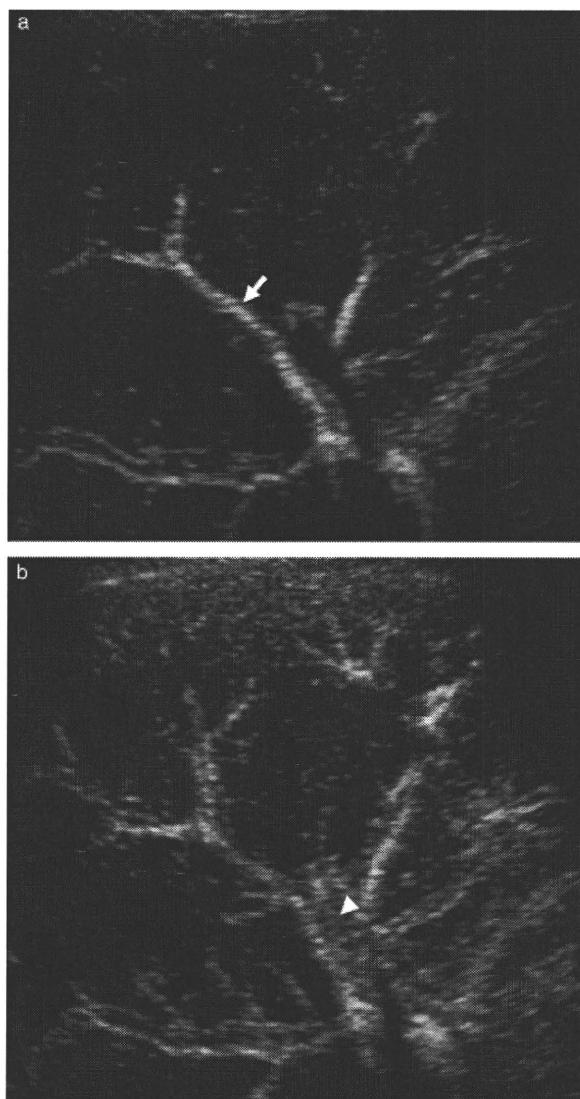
Contrast-enhanced ultrasound images under right intercostal scan. (a) Onset time of contrast enhancement in the right hepatic artery: onset time of contrast enhancement was 14 s after the injection of Sonazoid™ in the right hepatic artery (arrow). (b) Onset time of contrast enhancement in the right portal vein: onset time of contrast enhancement was 16 s after the injection of Sonazoid™ in the right portal vein (arrowhead).
